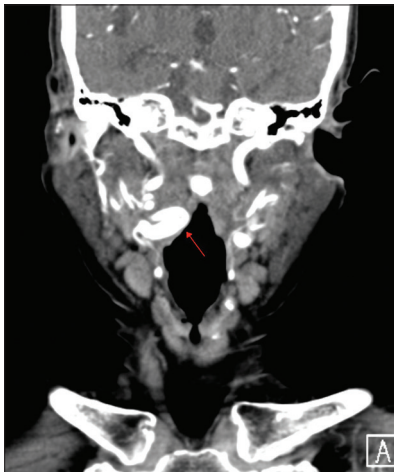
Coronal computed tomography angiogram shows a severe tortuous internal carotid artery impinging on the right pharyngeal wall (arrow)
